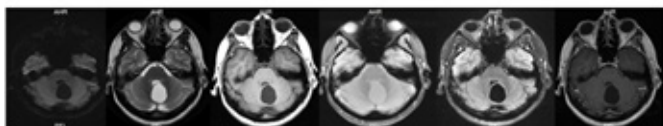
Follow up magnetic resonance imaging evaluation performed seven years following the initial MR evaluation demonstrates stable cyst size and signal characteristics are not enhancement. Imaging is performed in the axial plane, from right to left, and includes Diffusion Weighted Imaging, T2, and T1 weighted images, gradient echo, T2 FLAIR, and post gadolinium images.
